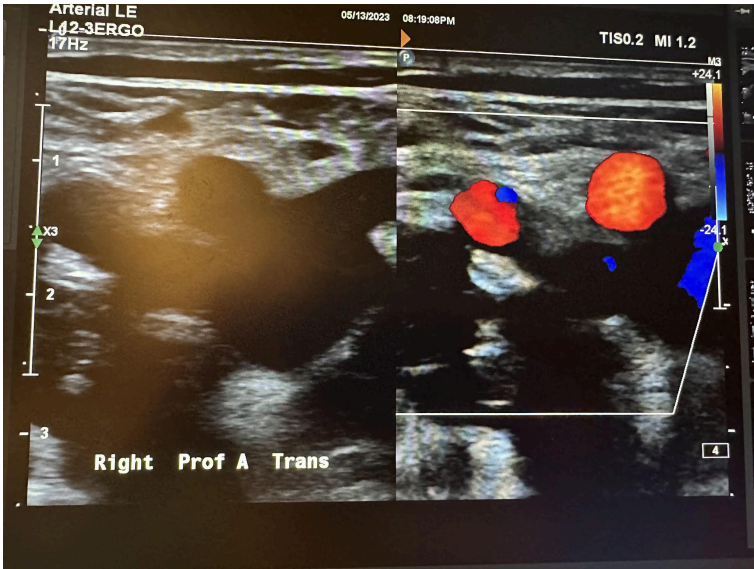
Side-by-side transverse images of the right profunda femoral artery without color Doppler and with color Doppler.
